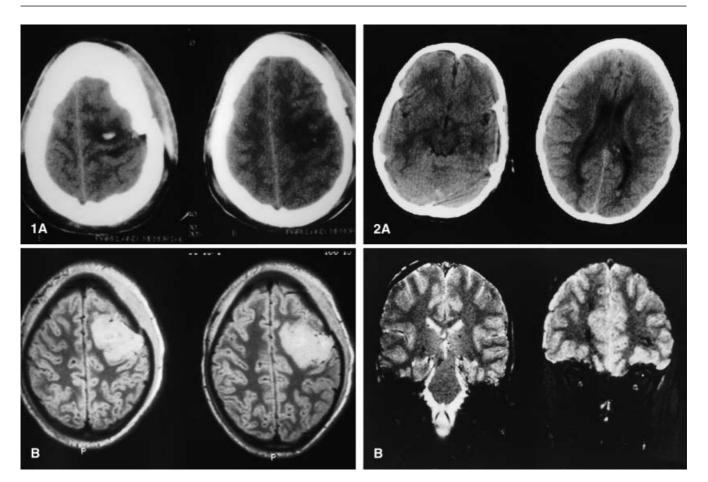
CT and MRI scans within the first 48 h of trauma. CT demonstrates the diffuse axonal injury much less well than does the MRI scan. The superior two images are CT scans, the inferior two are MRI scans
